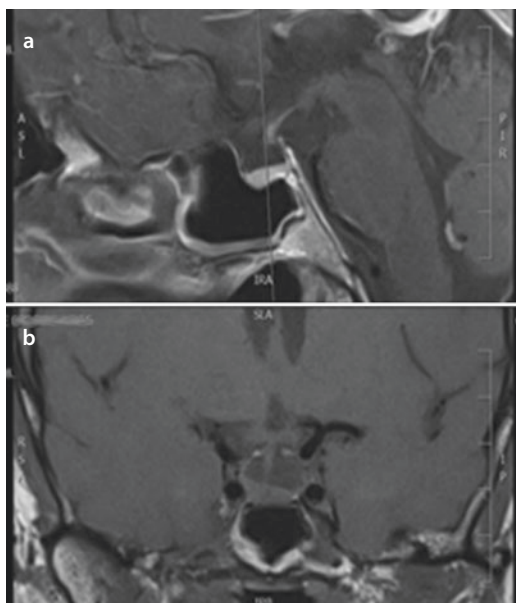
Idiopathic empty sella on a T1-weighted MRI (sagittal b and coronal a slices)
